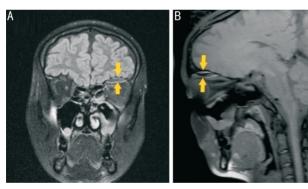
Coronal T2-weighted fluid-attenuated inversion recovery (FLAIR; A) and sagittal T1-weighted (B) MRI scans demonstrating a biconvex lesion (arrows) above the superior rectus muscle in the medial orbital roof, measuring 24×7, 2×25 mm².
